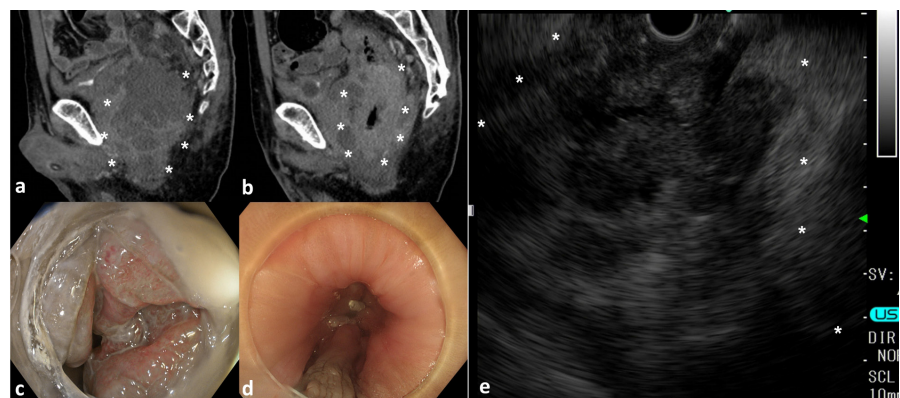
Computed tomography reveals a pelvic abscess (A; asterisk) around the rectal carcinoma (B; asterisk). Endoscopic ultrasound-guided pelvic abscess drainage (EUS-PAD) planned to avoid the tumor before the carcinoma operation, and the tumor margin is confirmed (C) with esophagogastroduodenoscopy and the clips placed to avoid puncture of the tumor (D). A pelvic abscess confirmed using EUS (E; asterisk).
